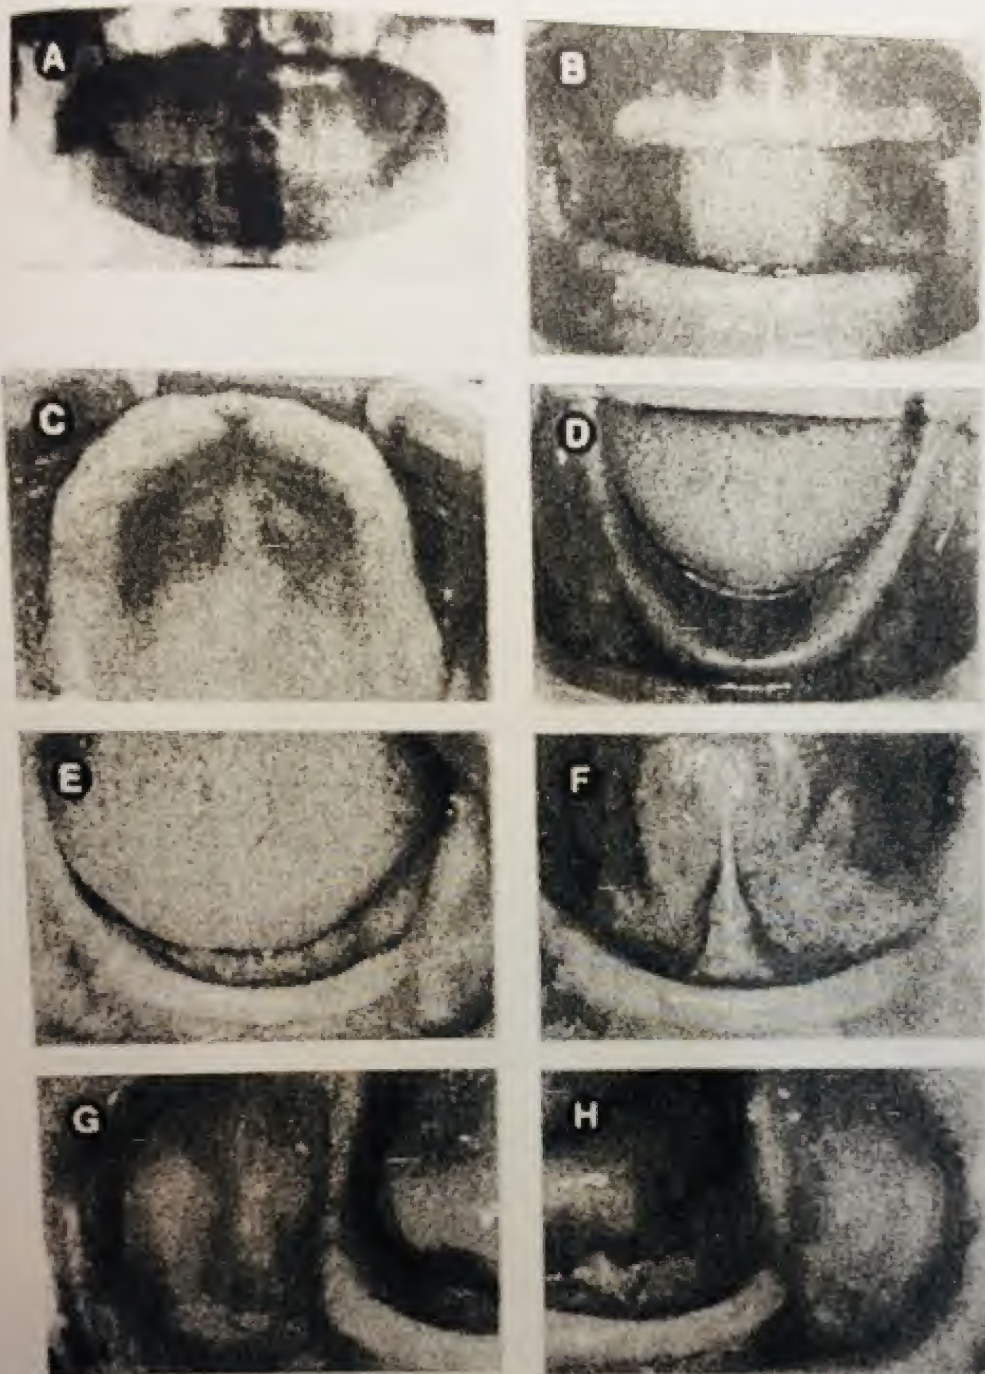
Class I patient. (A) Panoramic radiograph. (B) Facial view at the approximate occlusal vertical dimension. (C) Occlusal view: maxillary arch. (D) Occlusal view: mandibular arch. (E) Facial view: tongue in resting position. (F) Facial view: tongue elevated. (G) Lateral view of mandible: patient right. (H) Lateral view of mandible: patient left.
